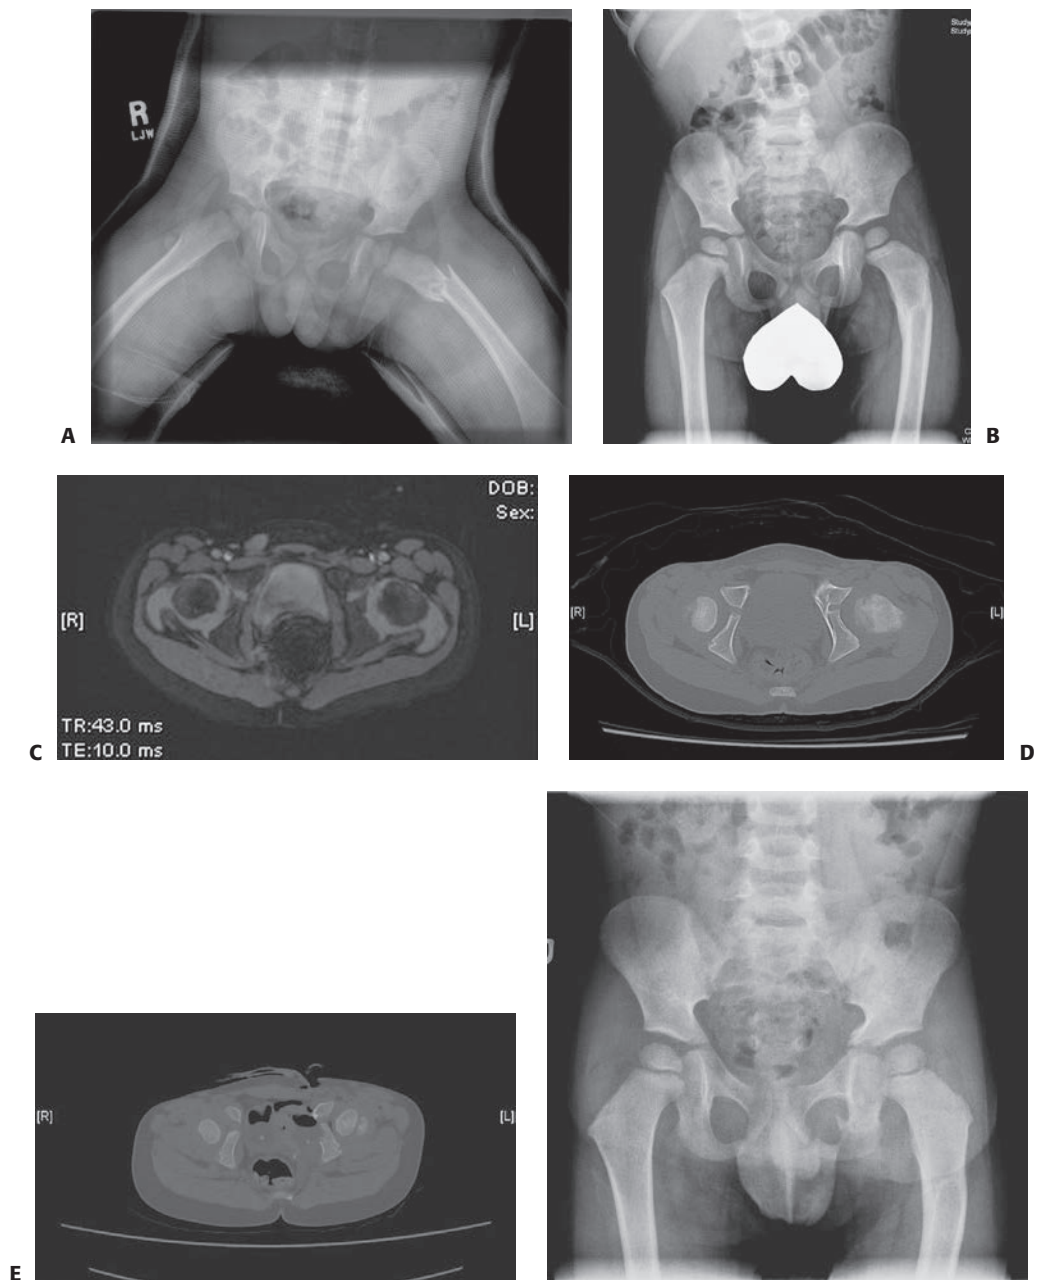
A: Radiograph of a 2-year old with a ramus fracture that involves the triradiate cartilage. B: Six months after the injury, there is indication of a physeal bar on the medial aspect of the triradiate cartilage. C: MRI confirming the presence of a physeal bar. D: CT scan confirming the physeal bar. E: CT scan confirming the physeal bar excision. This procedure was performed through an ilioinguinal approach and CT-guided excision. F: Radiograph of the pelvis after bar excision.
